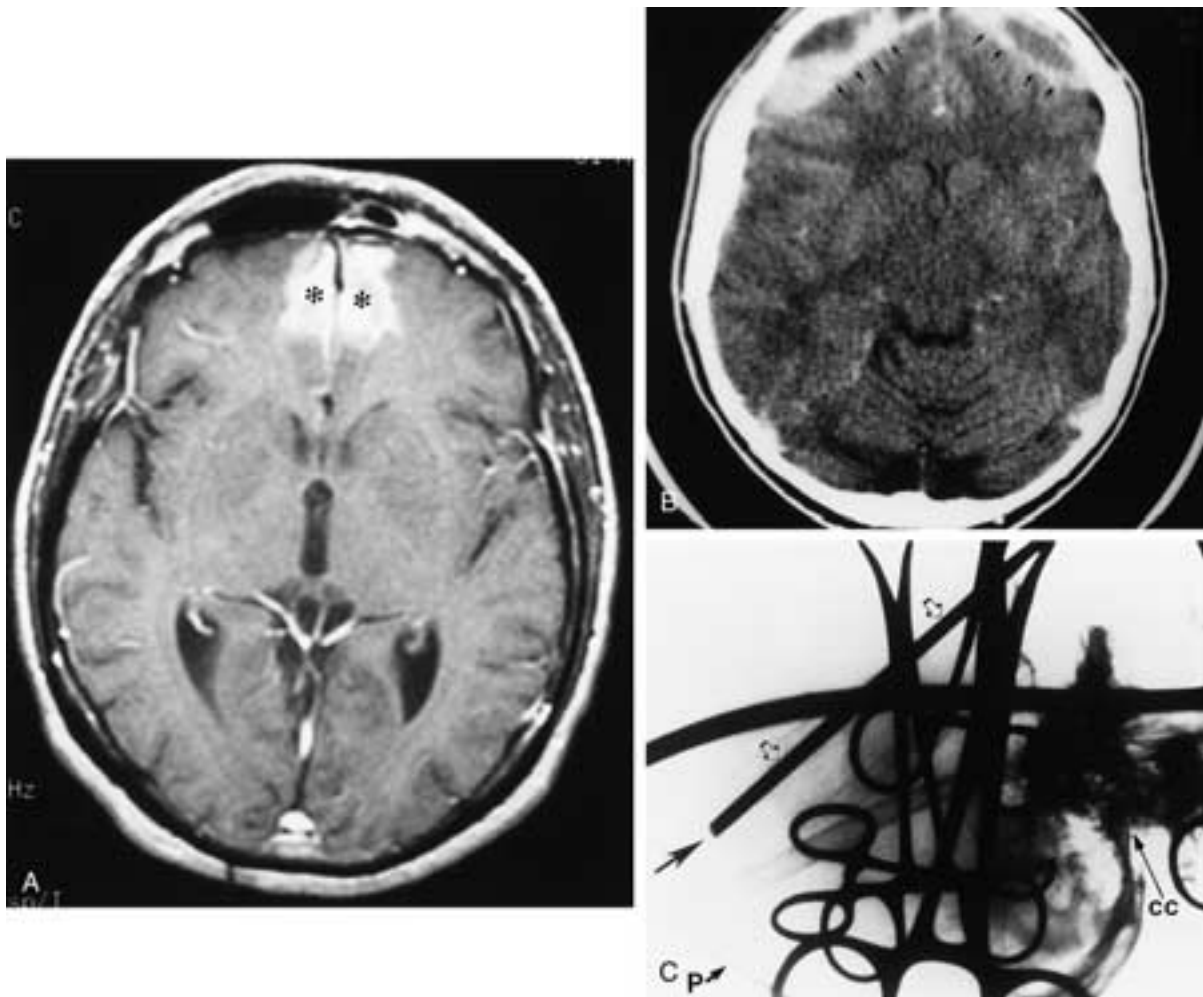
Intracranial complications from FESS. A, Axial T1-weighted MR image after gadolinium-DTPA administration shows abnormal bifrontal parenchymal enhancement (*asterisks*) caused by encephalitis from perforation through the cribriform plate. B, Axial CT image shows bilateral acute subdural hematomas (*arrows*) after FESS. C, Intraoperative cross-table lateral skull radiograph shows the intracranial extension of an endoscope (*open arrows*). Note the position of the endoscope in the deep portion of the posterior frontal lobe (*solid black arrow*). Overlying surgical instruments are noted. Craniocervical junction (*CC*) and parietal bone (*P*).
